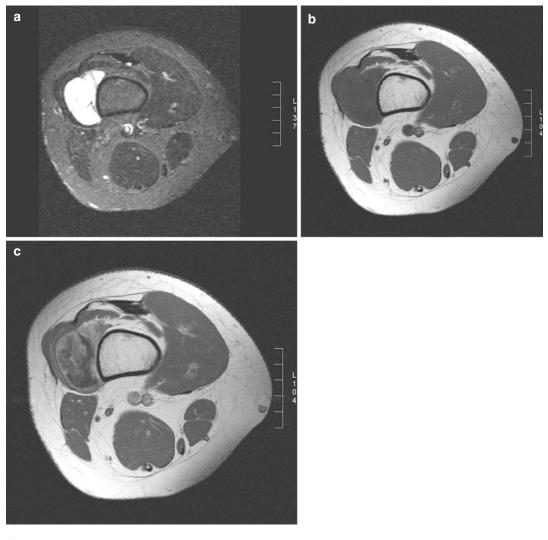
(a–c) Myxoid liposarcoma in the distal thigh. (a) Axial STIR sequence. A sharply margined mass lesion with homogeneous high signal intensity is interposed between the vastus lateralis muscle and the distal femur. (b) Axial unenhanced T1-weighted image. A very low tumor-to-muscle contrast is shown with the lesion's signal intensity slightly lower than muscle. In combination with the high signal intensity on STIR sequence, this lesion could be mistaken for a cyst based on unenhanced sequences alone. Also note the very high tumor-to-fat contrast, typical for unenhanced T1-weighted image. The lesion shows a definite and heterogeneous enhancement, inconsistent with a cystic origin of the lesion. Although there is a decreased tumor-to-fat contrast, delineation of the tumor from the adjacent fat still is perfectly possible. In addition, due to a clear increase in tumor-to-muscle contrast, this sequence is very suitable for surgical planning. Beside the adequate delineation of the tumor, this enhanced T1-weighted sequence improves the evaluation of the internal structure of the tumor. It helps to differentiate viable tumor from a cyst, with a totally different surgical approach, and helps to select an appropriate biopsy site. Because it mainly consists of less well-vascularized and myxoid or necrotic tissue, a biopsy in de posterior part of the lesion should be avoided
